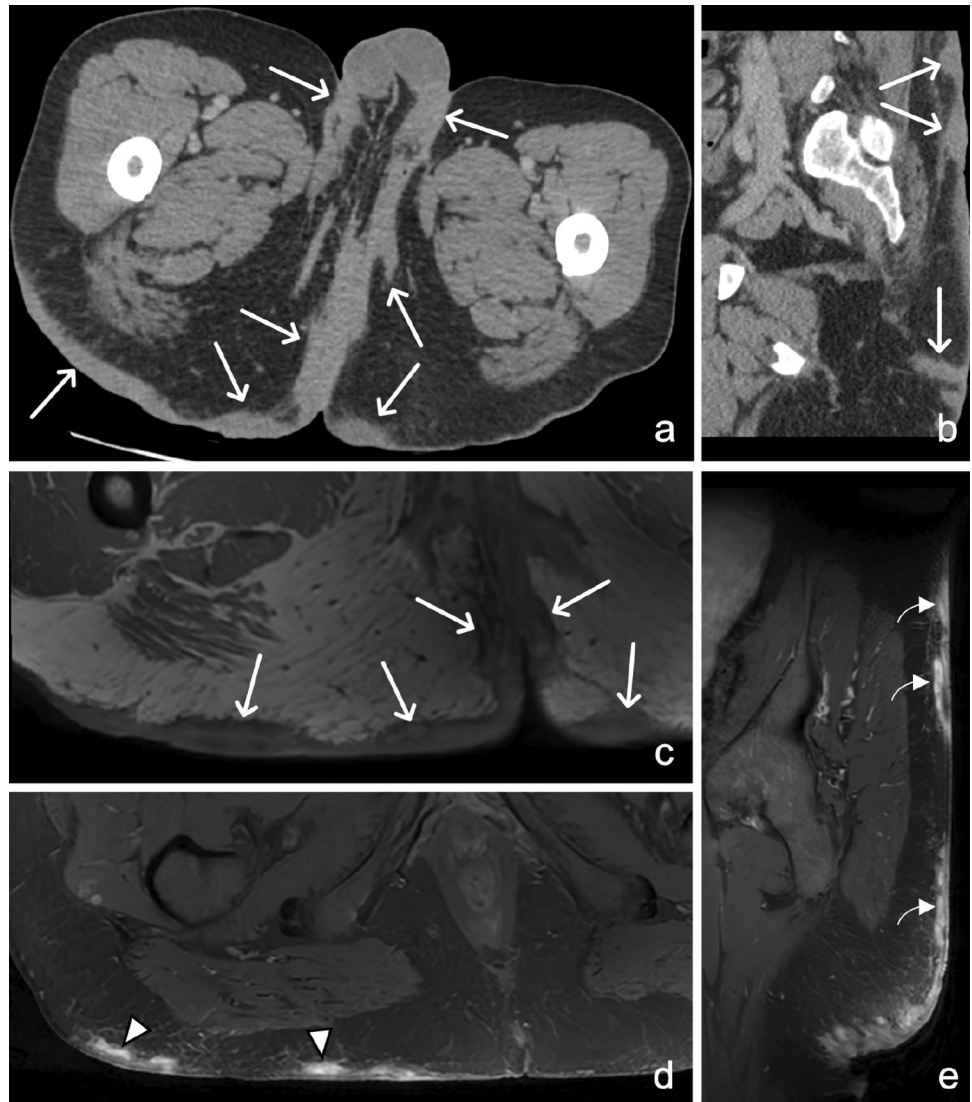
30-year-old male with Hidradenitis Suppurativa (HS). Axial (a, b) and coronal (c) CT reformat through the gluteal cleft and perineum demonstrate nodular, bilateral, fairly symmetrical subcutaneous soft tissue thickening (arrows) with sinus track formation (arrowhead) in a patient with pathologically proven HS. Contrast these findings
